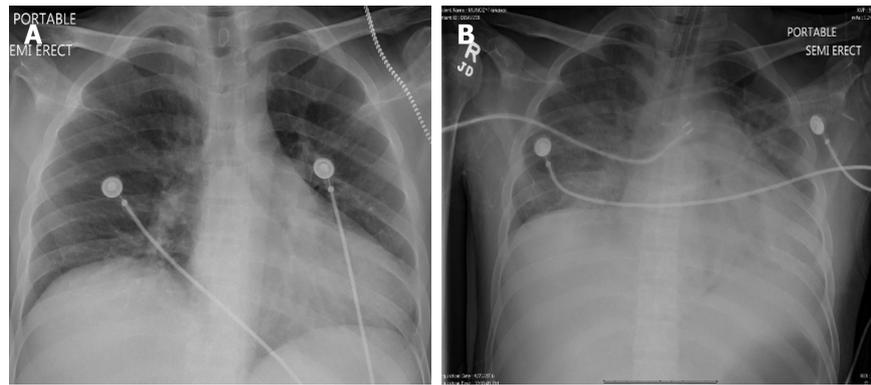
X-ray chest (case 2). A: X-ray chest with no infiltrates at the time of admission; B: X-ray chest with new infiltrates and hypoxia requiring intubation and mechanical ventilation.
